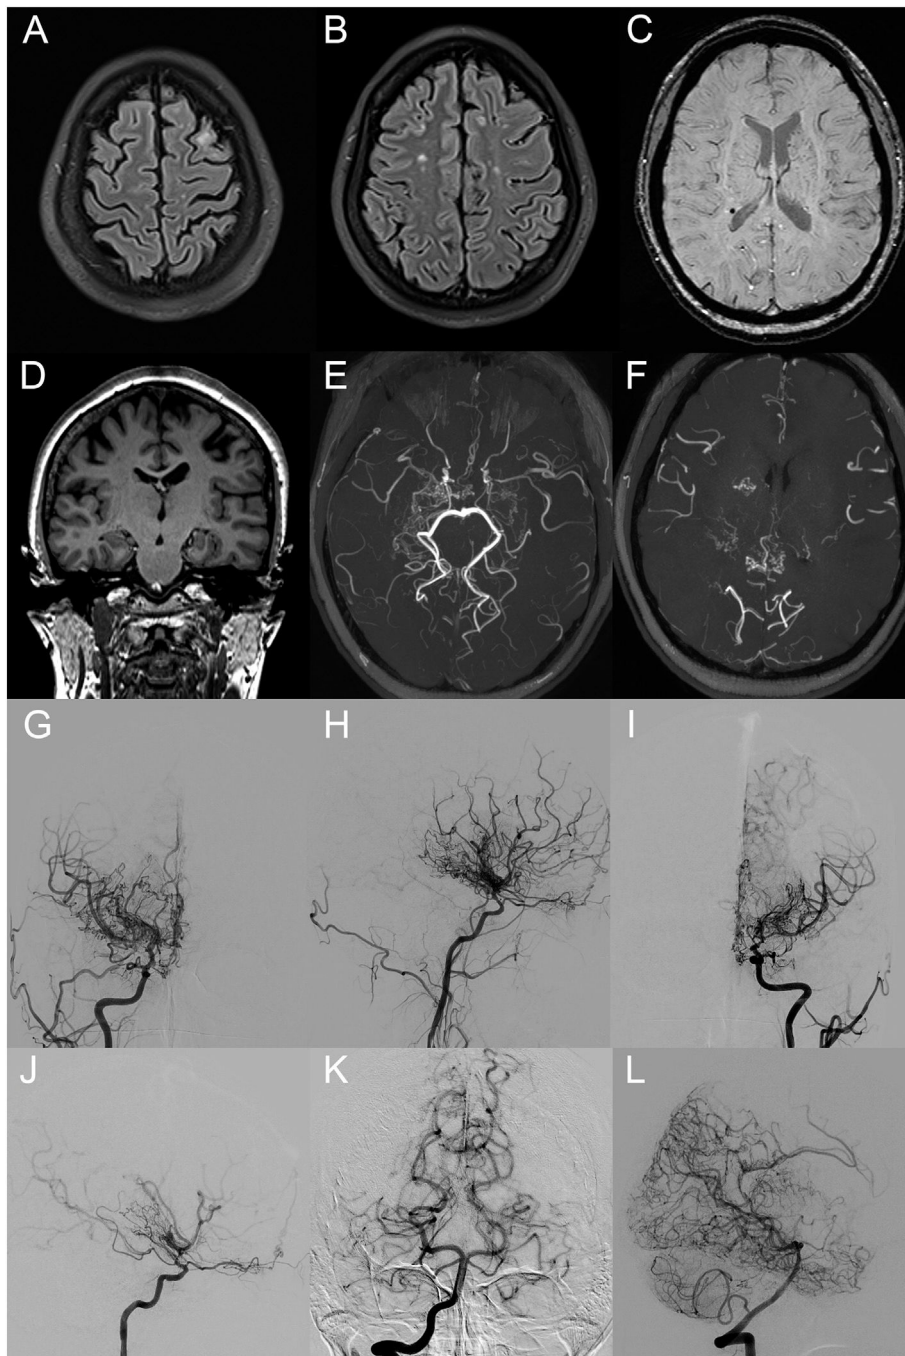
Imaging study in the patient presented. A–F. Brain magnetic resonance (MR) study. Axial T2 FLAIR images showed chronic cortical lesions in the left frontal cortex (A), and several subcortical gliotic foci in the white matter of both hemispheres (B). C. Axial SWI image evidenced deep left periventricular microbleed. D. Coronal T1 image showed hippocampal asymmetry suggestive of left hippocampal malrotation. E, F. Axial time of flight (TOF) MR sequence showed severe bilateral stenosis at the terminal internal carotid artery portion, decreased flow signal in M1 segments of both middle cerebral arteries, an increase in the diameter of both posterior cerebral arteries, as well as, abundant collateral vessels in basal ganglia and basal cisterns, which were more predominant in the right hemisphere. Pial collateral vessels were also observed (F). Altogether, these changes resulted in a decreased flow in both hemispheres, especially in the left one (E, F). G–L. Cerebral arteriography study in the patient. Anterior (G, I) and lateral (H, J) projection views showed critical stenosis at the terminal portion of right (G, H) and left (I, J) internal carotid arteries, together with an important network of collateral vessels originating from the lenticulostriate, ophthalmic and anterior choroidal arteries (G–D). Posterior (K) and lateral (L) projection views showed increased bilateral posterior cerebral artery diameter (K) and multiple pial collaterals from the posterior cerebral arteries (L). No extra-intracranial anastomoses were observed. Altogether, these findings confirmed the diagnosis of moyamoya disease, classified as Suzuki and Takaku's stage III.
